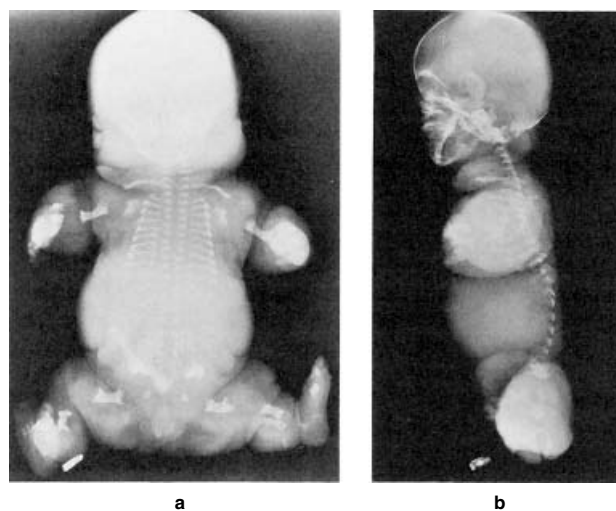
Radiographs of an infant with achondrogenesis type II (a, b), showing markedly short ribs, hypoplastic ilia, and flat acetabular roofs. The long bones are extremely short and broad with irregular, cupped metaphyses. The vertebral pedicles are ossified but the bodies are not.
